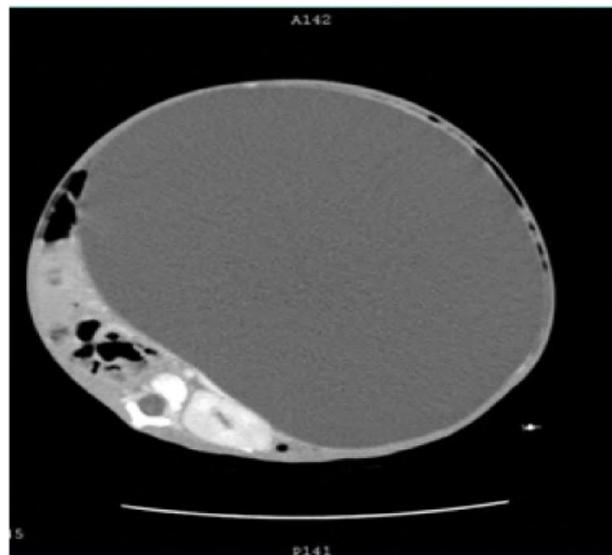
CT scan showing massive hepatic cyst
